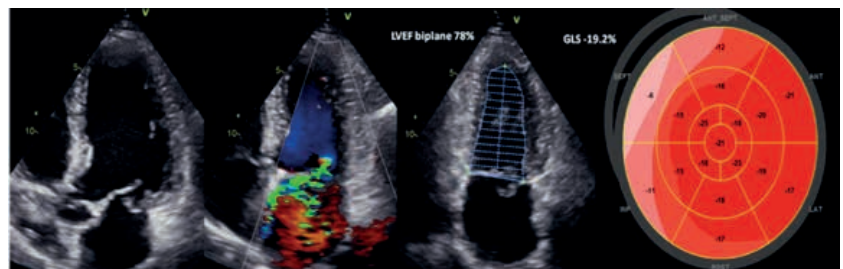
A case of an asymptomatic patient with primary organic mitral regurgitation due to posterior leaflet prolapse and preserved left ventricular ejection fraction (LVEF 78%) who has impaired global longitudinal strain by speckle tracking echocardiography (GLS -19.2%). According to the impaired GLS that was worse than -20% the patient was considered for surgical mitral valve repair.
